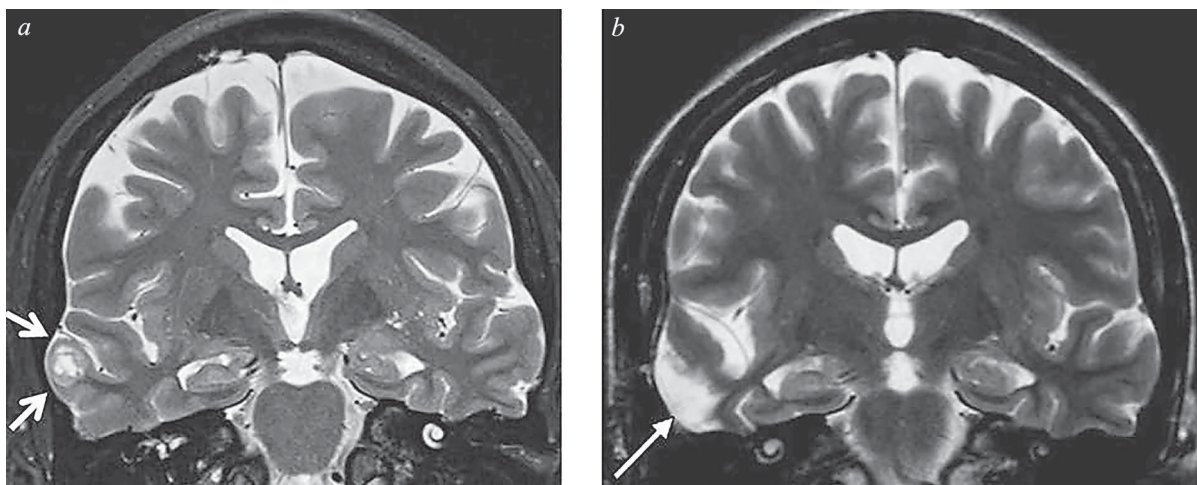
MRI, clinical case 3. a) T2 coronal section, preoperative; b) T2 coronal section, postoperative.
